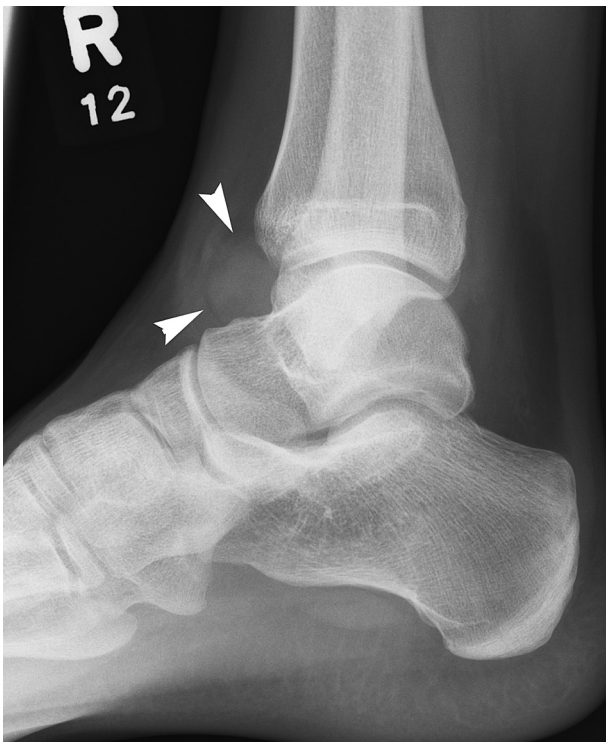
Lateral radiograph demonstrates an ankle joint effusion (arrowheads) but no fracture following trauma.
